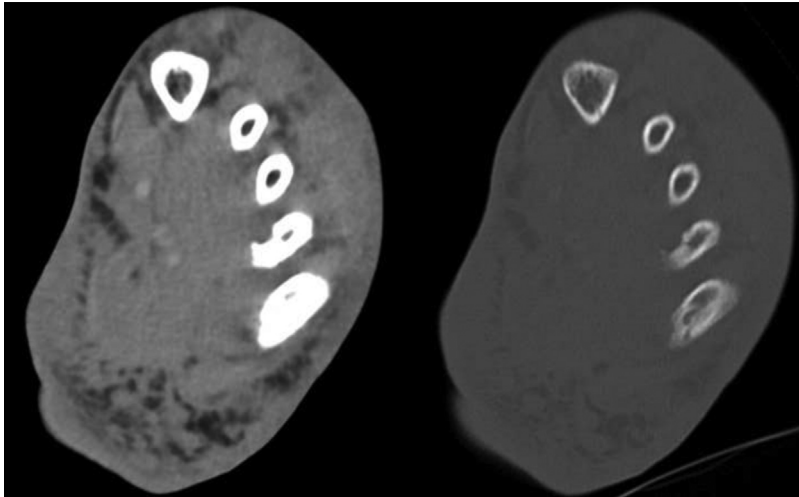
Case 2. CT scan confirmed osteomyelitis, that we can see here on the 4th and 5th metatarsal bones.
